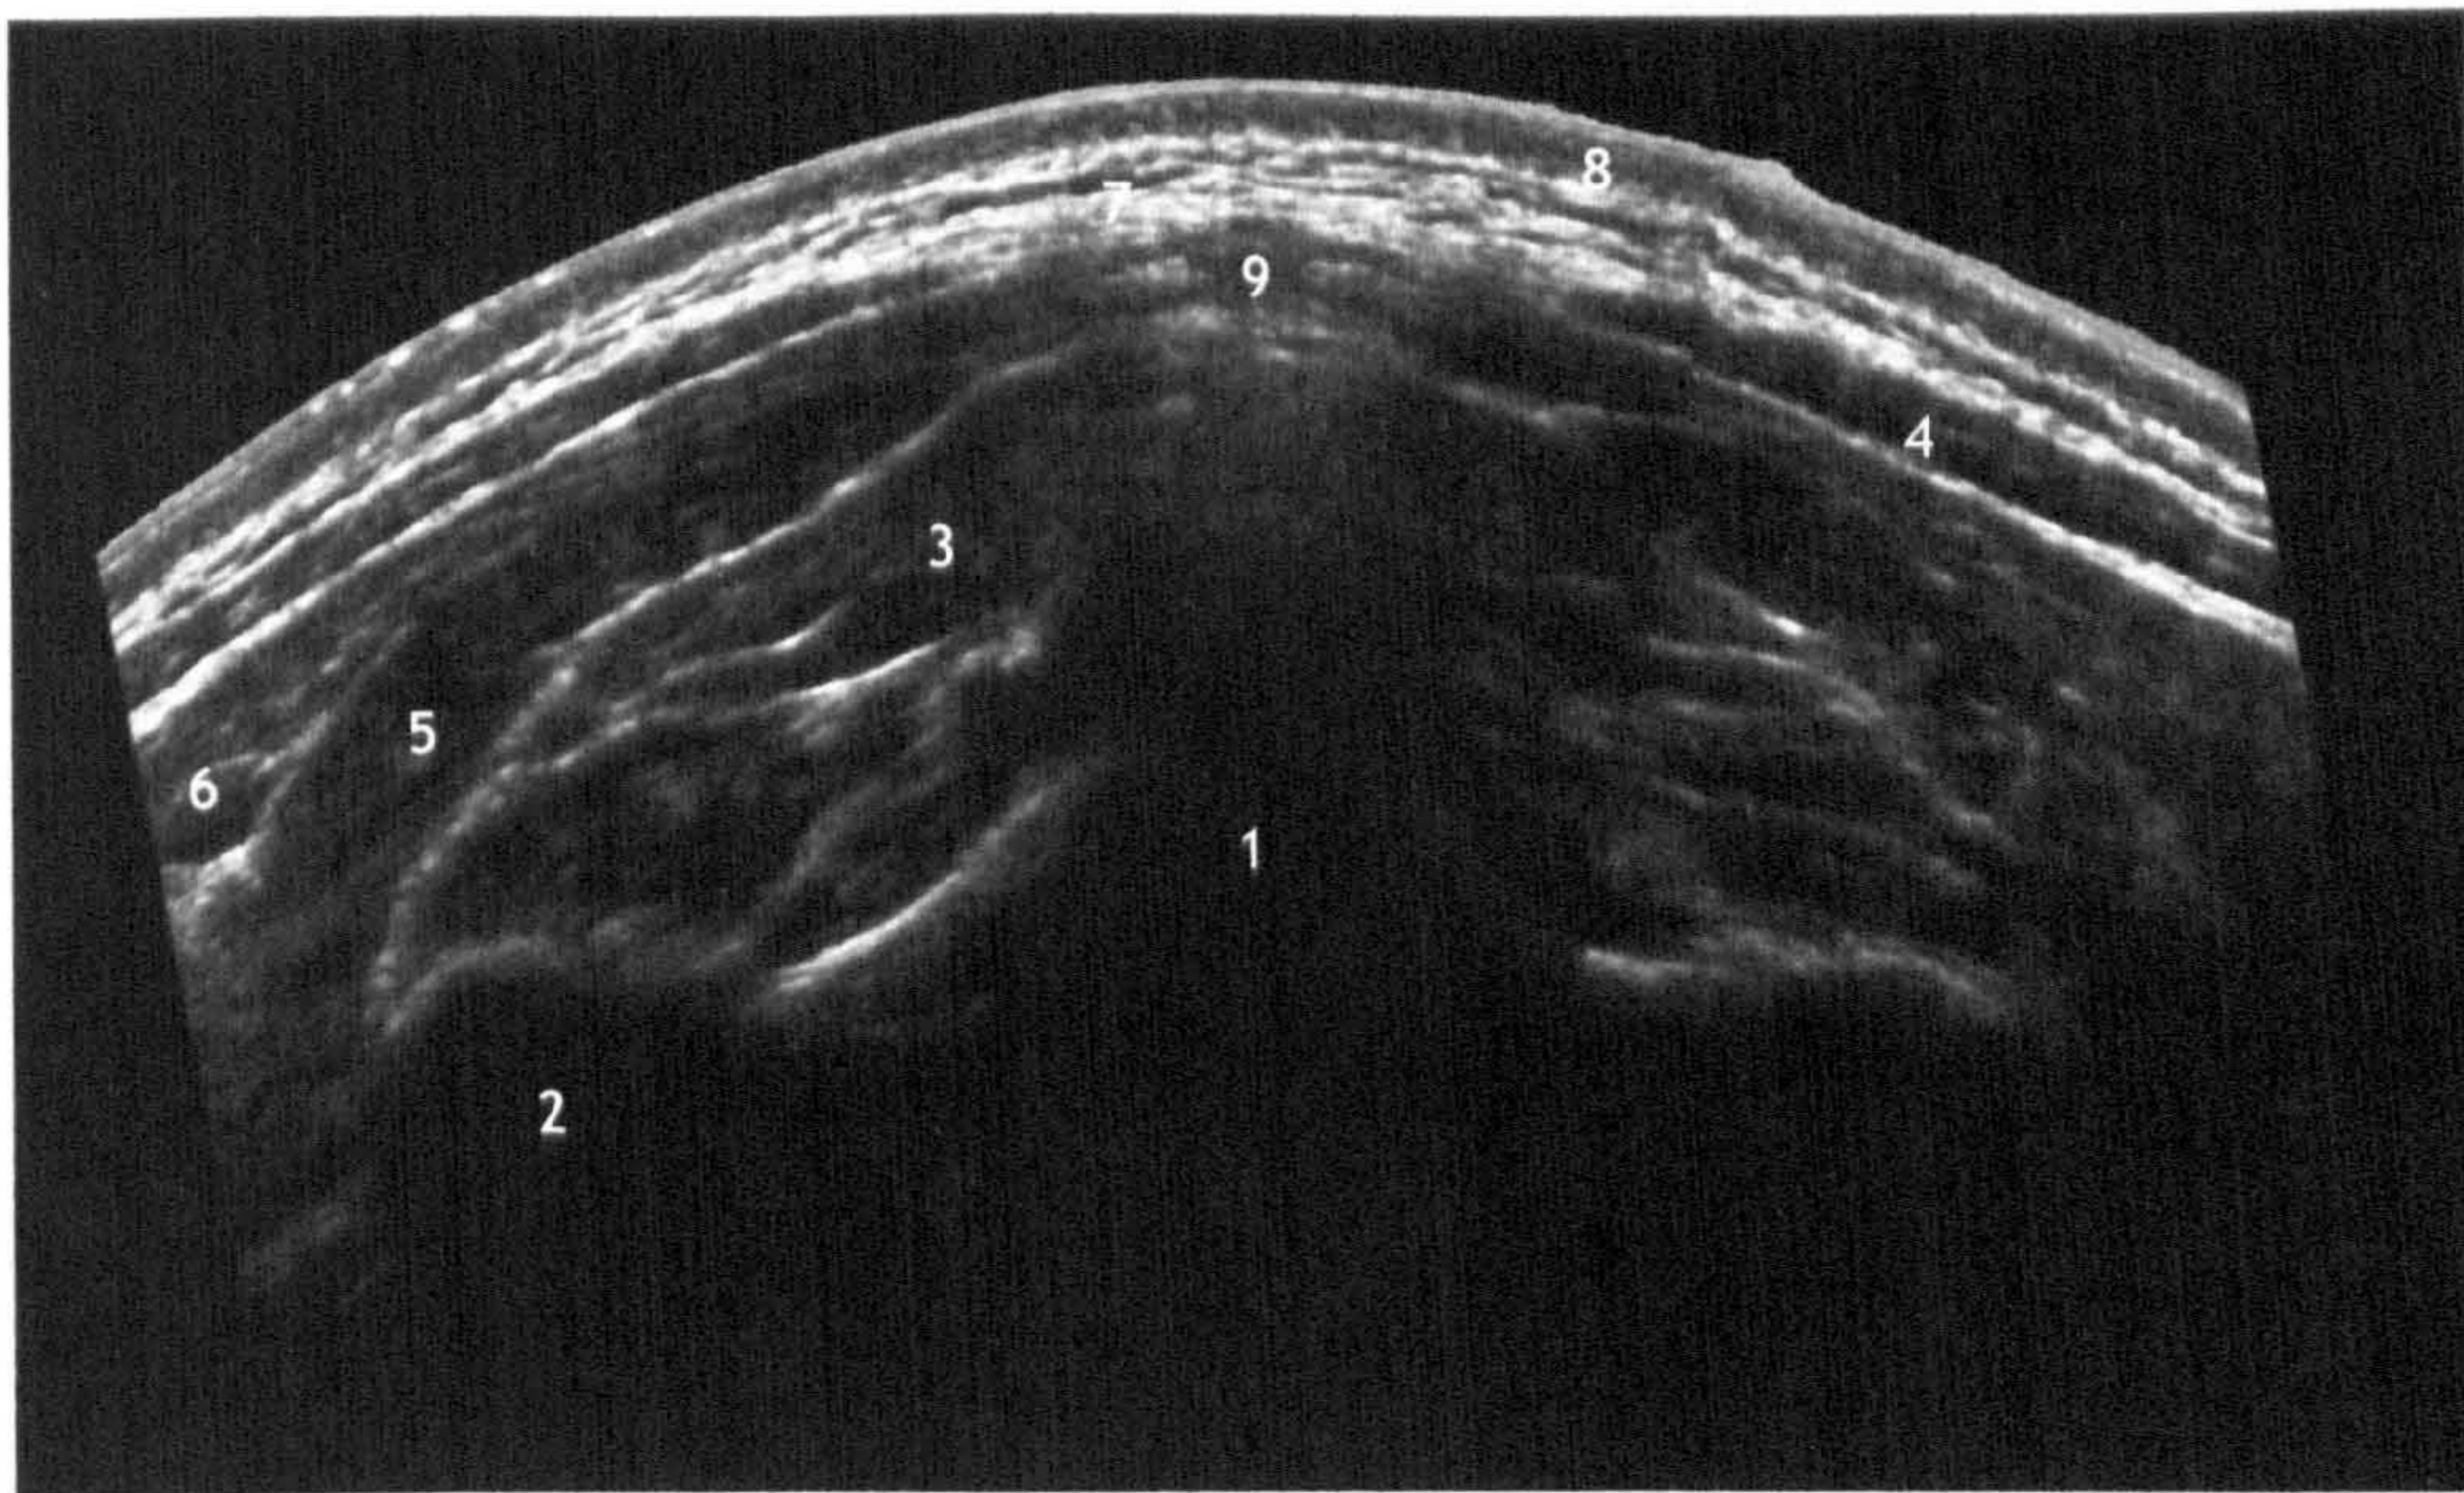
Ultrasound of the posterior neck
